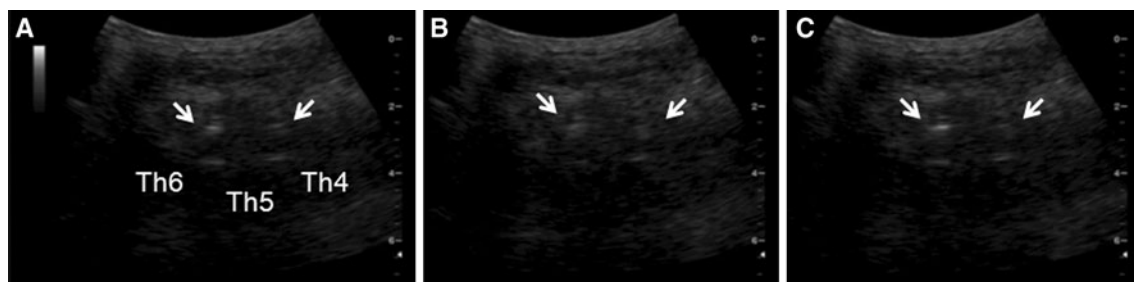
a Longitudinal ultrasound imaging of the T4–T6 (Th4, Th5, Th6) spinal canal in a 5-year-old child. *Arrows*, dorsal dura mater. a–c Sequence ultrasound imaging of thoracic epidural catheter in the longitudinal view. The dorsal dura mater and that of the T5–T6
